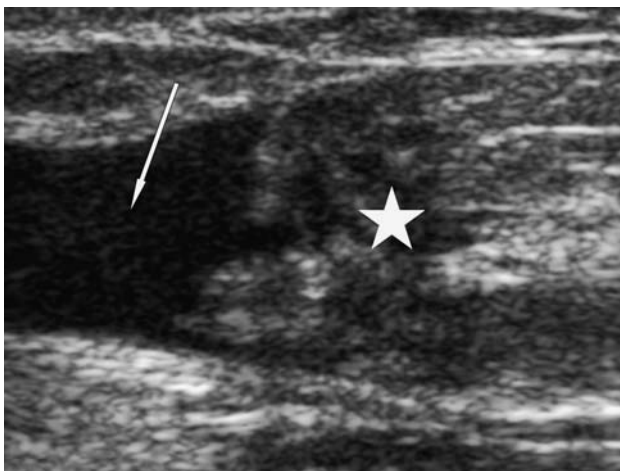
Axial ultrasound image of the pectoralis muscle at the level of the anterior axillary fold. There is a fluid collection seen (arrow) and, more medially, the retracted muscle together with the tendon (asterisk).
